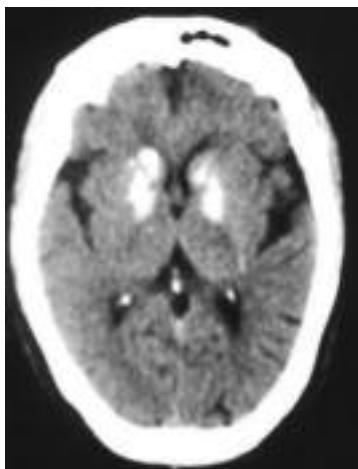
Brain CT scan of Patient IV-4 showing calcifications of basal ganglia
